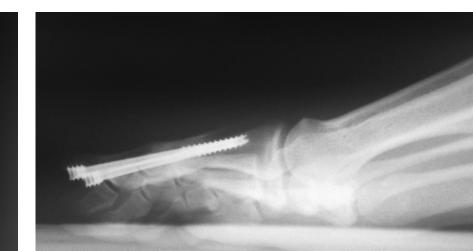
(left): AP radiograph of a single 4.0-mm screw Figure 2 (middle): AP radiograph of two 3.0-mm headless screws
